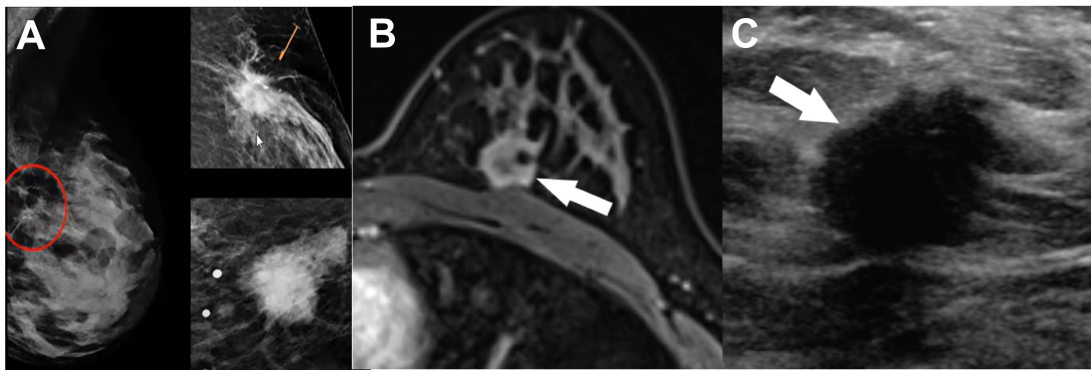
Imaging features of Luminal B subtype: A) At mammogram showed a microlobulated spiculated mass with indistinct margins and architectural distortion, B) on MRI there is an enhancing irregular mass with spiculated margins , and C) on US a hypoechoic with irregular mass is observed.
